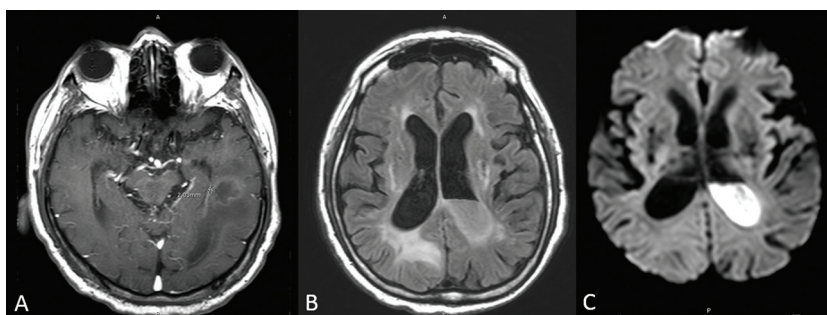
Left temporal abscess with intraventricular rupture. (A) Axial contrast-enhanced T1-weighted image demonstrates a well-defined, thin enhancing rim lesion at left temporal lobe. (B) Axial FLAIR image demonstrates fluid-debris level within ventricle after abscess rupture. (C) Axial diffusion-weighted image demonstrates restricted diffusion of fluid-debris level.
